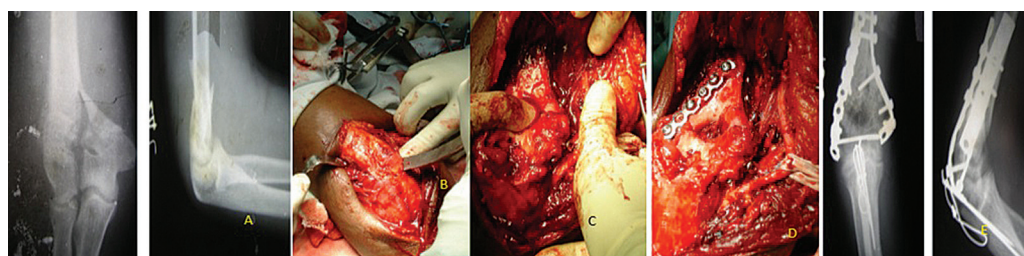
The radiograph of the left elbow showing a Y-shaped fracture of the distal humerus: anteroposterior (left) and lateral (right) views (A). Posterior approach with olecranon osteotomy (B). Temporary reduction of the fracture (C). Fixation of the fracture with orthogonal plating (D). Postoperative X-rays anteroposterior (left) and lateral (right) views (E).
